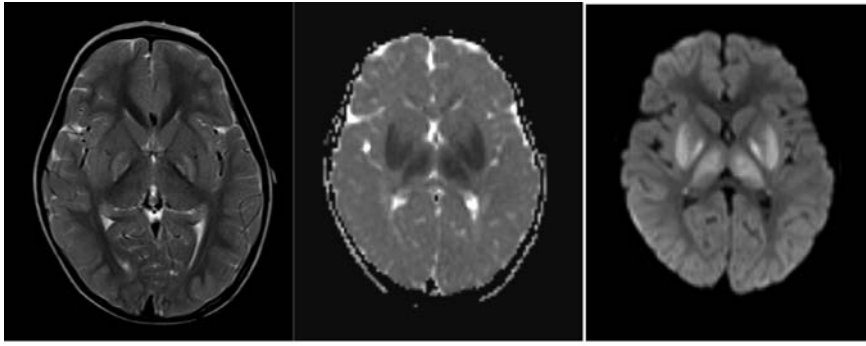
T2-weighted and diffusion weighted images. Increased intensity on both globus pallidus is present on T2-weighted image. Restricted diffusion is prominent on both thalami, putamina and globus pallidus.
